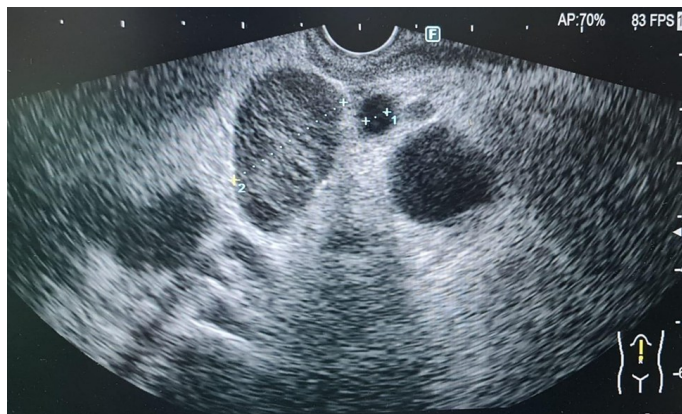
Endoscopic ultrasound showing enlarged peri-portal, peri-hepatic and peri-pancreatic lymph nodes.
